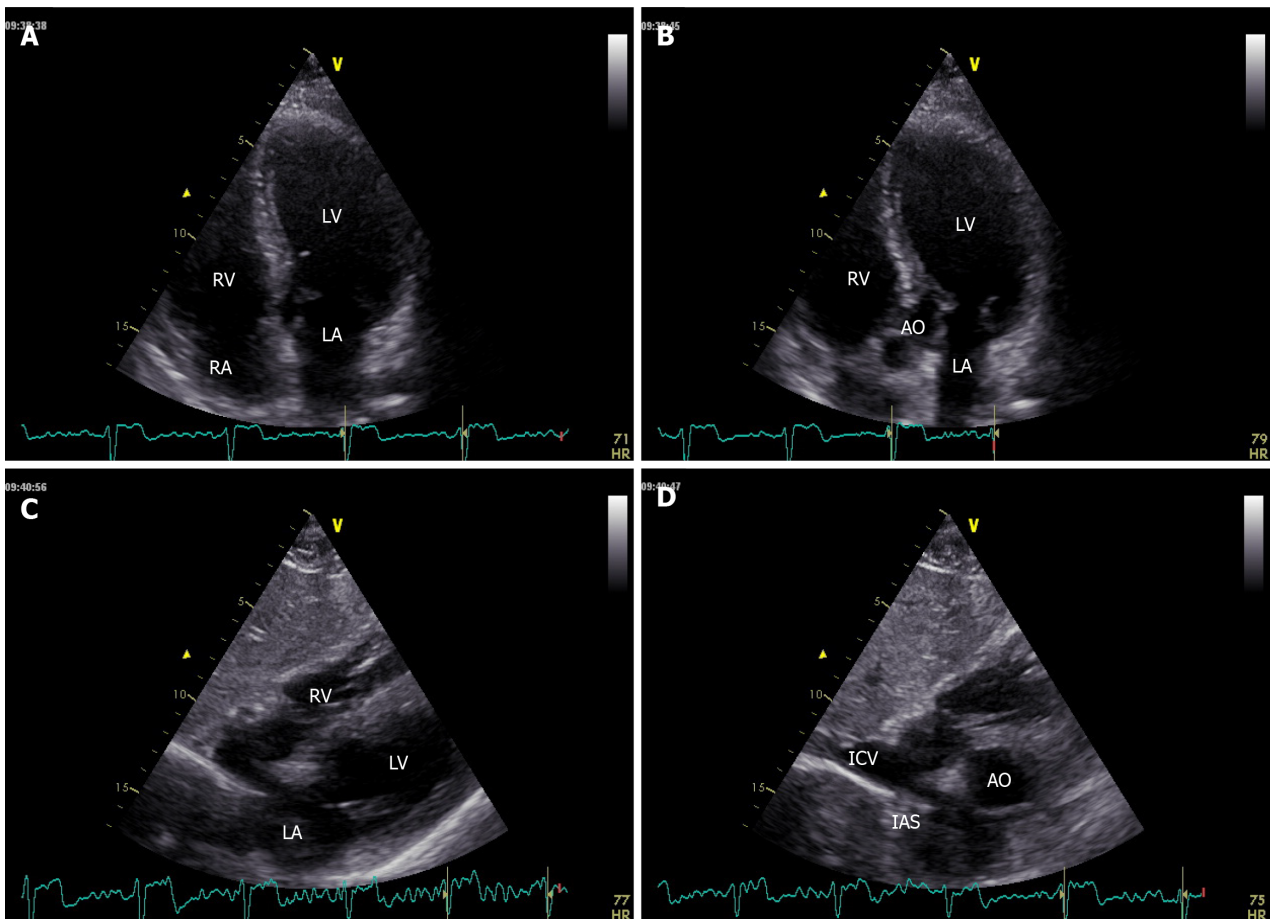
Apical 4-chamber, 5-chamber and subcostal windows showing left and right chambers, inferior cava vein and pericardium. A: 4-chamber; B: 5-chamber; C and D: Subcostal windows. LV: Left ventricle; LA: Left atrium; RV: Right ventricle; RA: Right atrium; AO: Aorta; IAS: Interatrial septum; ICV: Inferior cava vein.
